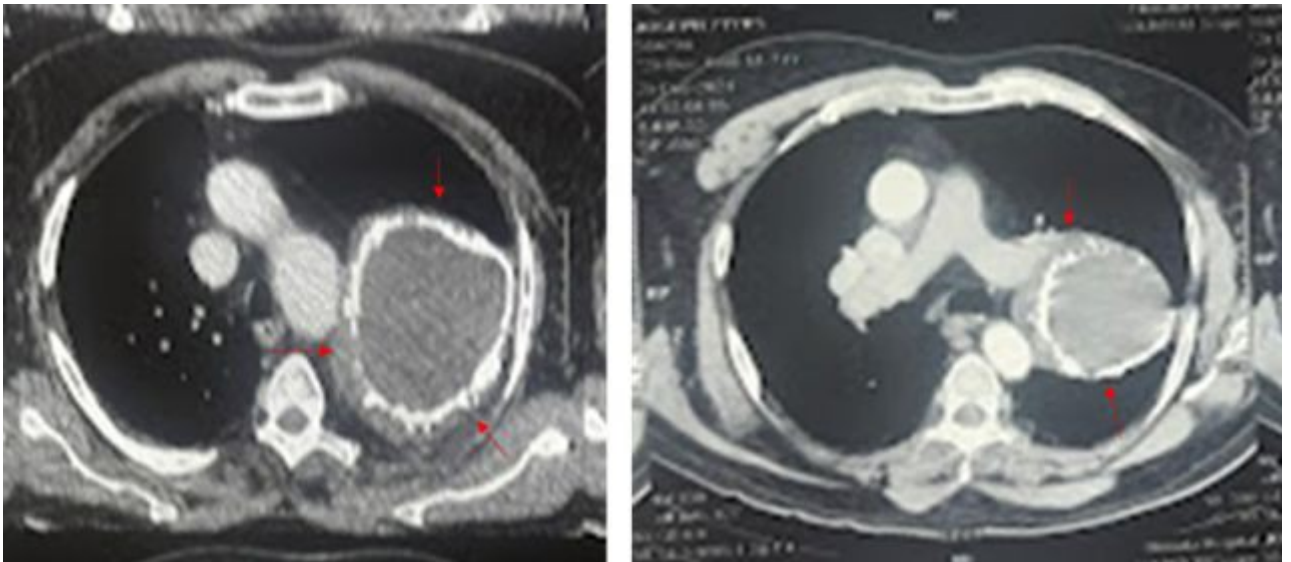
CT Thorax mediastinal windows showing a large cystic mass occupying the left upper lobe with rim of calcification (Ring calcification). The cyst is in close proximity to the descending aorta and left pulmonary artery with the visible fat plane.
